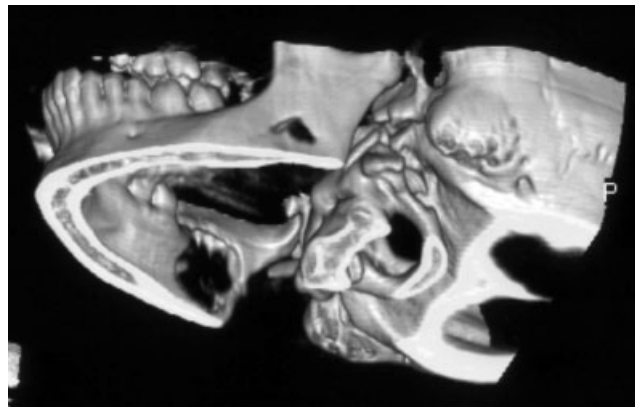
Three-dimensional CT reconstruction: the erosion of the mandibular cortical bone is evident on both sides
